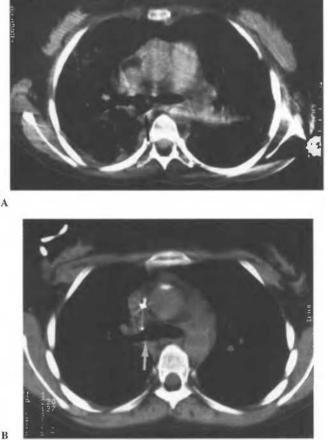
CT scans from the same patient depicted in Figures 2 and 3. A: CT scan taken at 4 weeks post-transplant, demonstrating the dehiscence. B: CT scan taken 4 months later, showing a healed bronchus and no extrabronchial mediastinal air. Note again that the lumen of the bronchus is wide open with no stenosis
